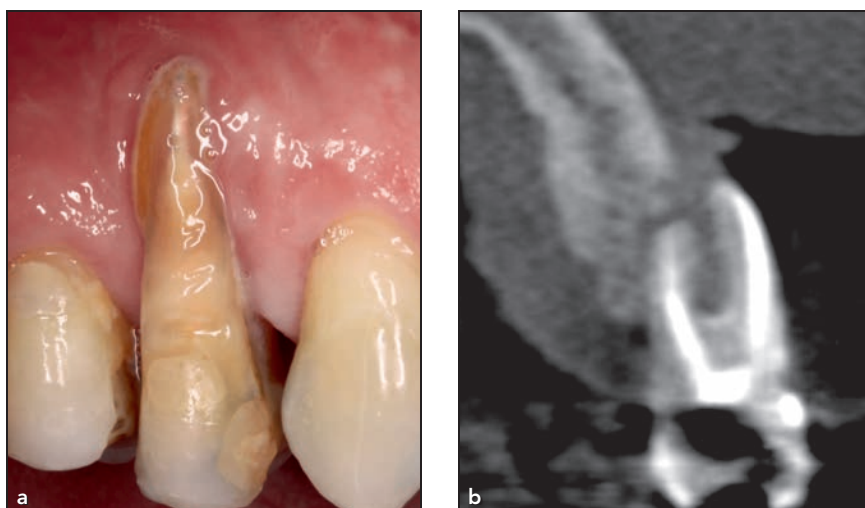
Case 1. (a) The patient's maxillary right first premolar presented with a major buccal and mesial periodontal defect and was indicated for extraction. (b) The initial CBCT scan shows the absence of the buccal and palatal bone walls.
